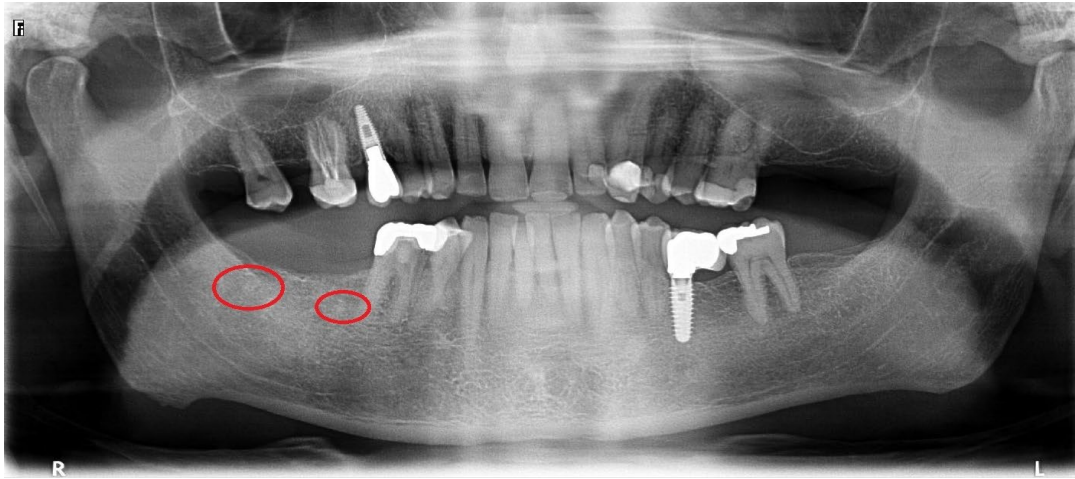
Pre-procedure orthopantomography
